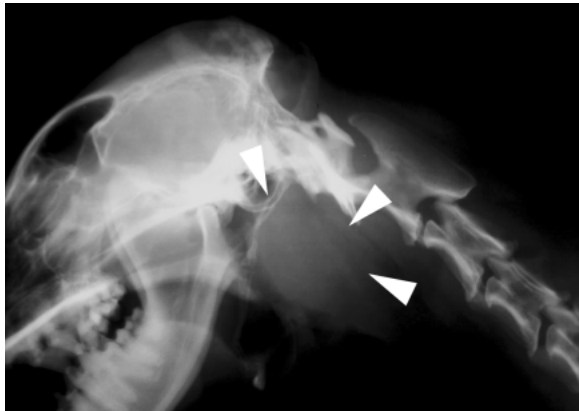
Left lateral head radiograph demonstrating an abnormal mass (arrowheads) in the retropharyngeal site.
